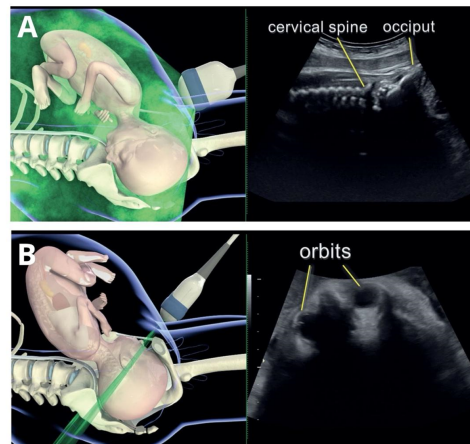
Sonography for diagnosing fetal spine and head position during labor. A suprapubic transabdominal sonography identifies an anterior fetal spine and occiput in an occiput anterior fetus (A) and anterior fetal orbits in an occiput posterior fetus (B).
